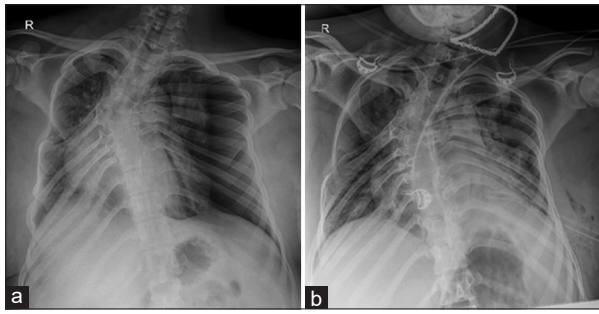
(a) X-ray image of the chest showing left-sided pneumothorax with mediastinal shift to the right; (b) X-ray image of the chest post-international classification of diseases insertion, showing re-expanded left lung
